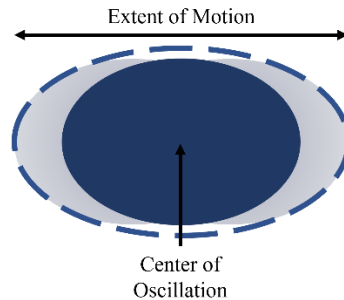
Depiction of the motion blurring effect. Darker mass represents the region always populated by lesion mass and shaded regions represent areas affected by the oscillation blurring of the FDG in the lesion.
